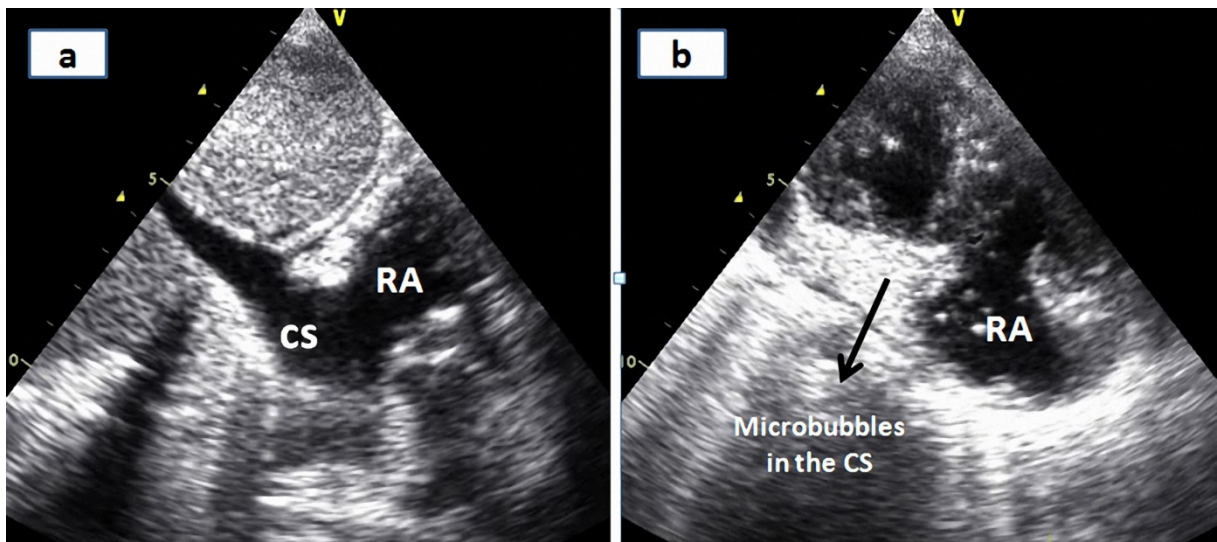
Intravenous injection of agitated saline from right brachial vein showed contrast enhancement of an enlarged CS, before the right atrium by transthoracic echocardiographic subcostal view. This finding demonstrated a PLSVC and the absence of a right superior vena cava.
